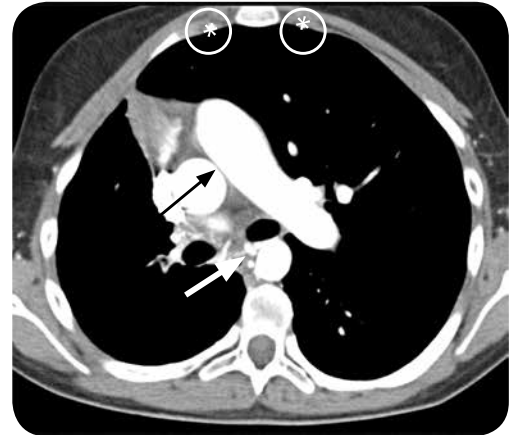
Angio CT of the thorax, axial, window to the mediastinum. Absence of the right pulmonary artery (black arrow), dilation of bronchial arteries (white date). Asymmetry in the diameter of the internal mammary arteries (circles).
